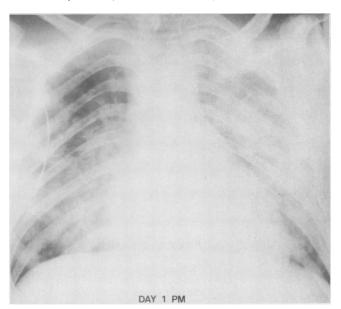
An anteroposterior chest radiograph of the patient in case 7 taken on the fourth day of illness, 20 hours after admission, shows more coalescent densities bilaterally, which appear more like pneumonia than pulmonary edema.
